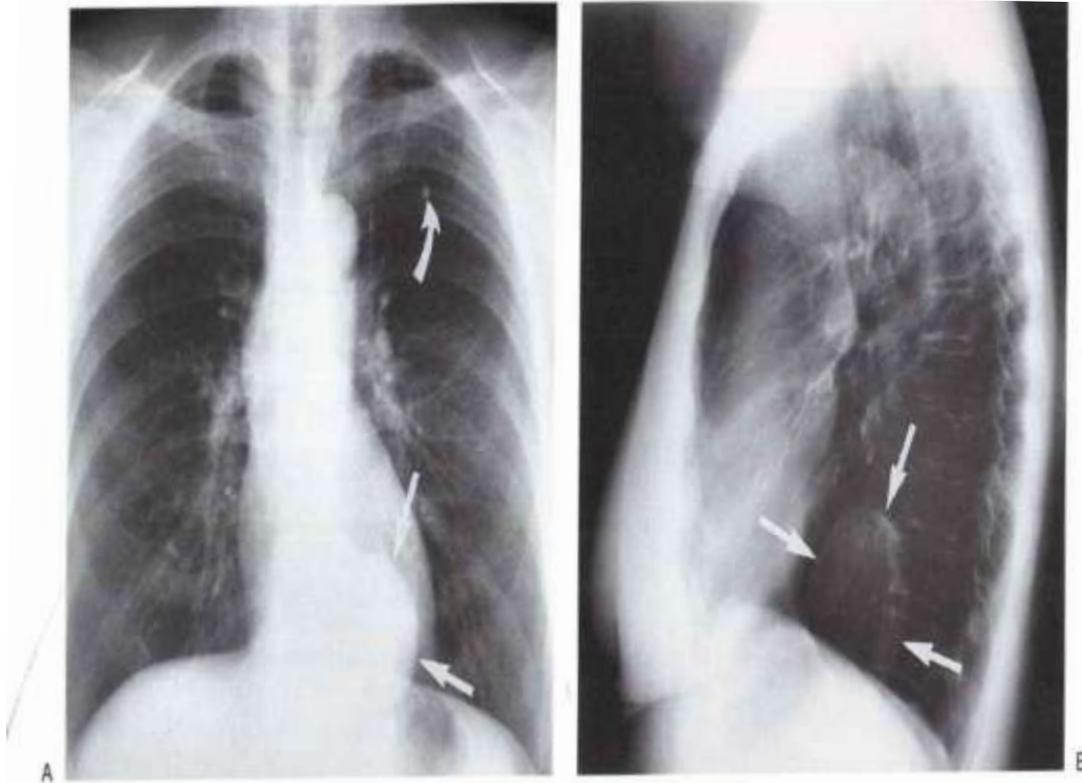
Descending thoracic aortic aneurysm. A: PA chest radiograph of a 69-year-old woman shows a rounded mass in continuity with the descending aorta (*straight arrows*). Incidental note of calcified granuloma in the left upper lobe (*curved arrow*). B: Lateral chest radiograph shows curvilinear rim calcification within the wall of the aneurysm (*arrows*).
